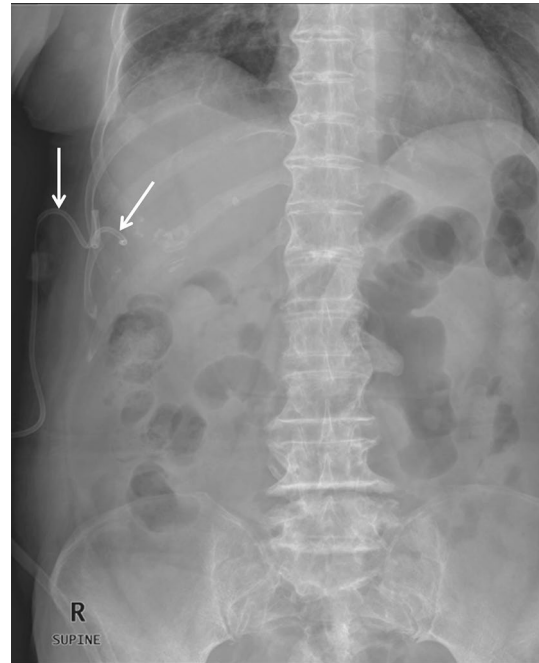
Cholecystostomy catheter migration in an 87-year-old female with cholecystitis. Abdominal radiograph shows a catheter (*arrows*) that has backed out of the gallbladder. Subsequently, the catheter was removed and a new catheter was properly placed (not shown)
